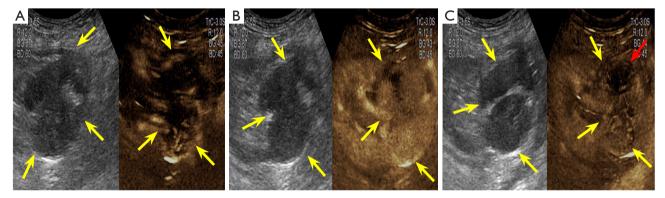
CEUS manifestations of kidney graft. (A) CEUS revealed that the edge of the mass started enhancing at 16 seconds in the arterial phase. (B) CEUS during the arterial and parenchymal phases revealed that the peak enhancement of this mass was the same as that of the surrounding renal parenchyma, which was called hypo-enhancement, and an irregular non-enhancement area in the mass. (C) At 1 min 49 s, CEUS revealed that the mass had an early washout pattern. The yellow arrows indicate the location of the lesion. The red arrow indicates the non-enhancement area in the mass. CEUS, contrast-enhanced ultrasound.
